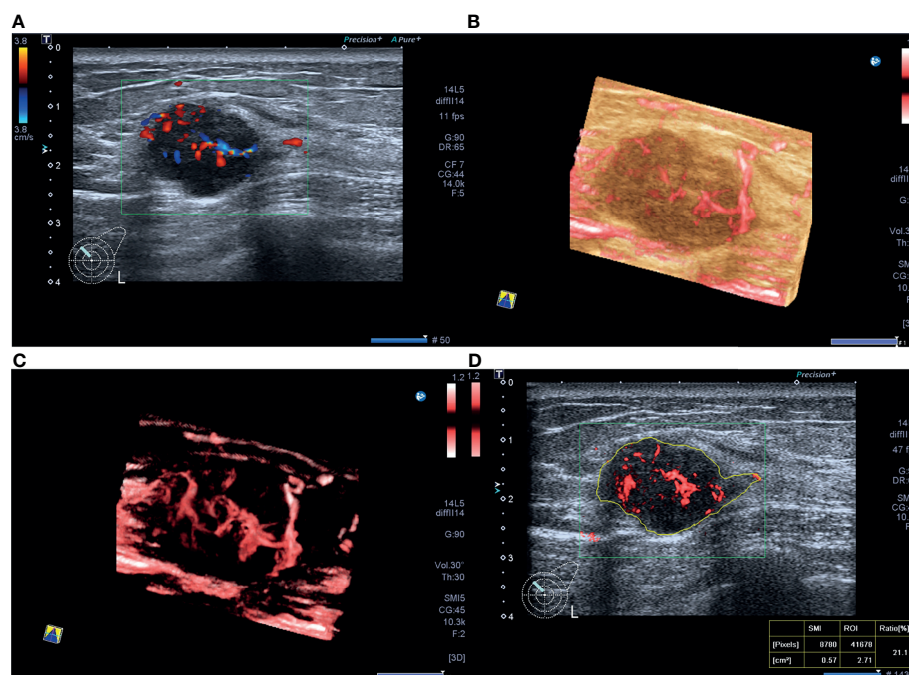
A 40-year-old woman with triple-negative invasive ductal cancer [2.3 cm, ER (-), PR (-), HER-2(-), Ki-67 95%, nuclear grade 2, T2N1M0]. (A) Color Doppler flow image shows abundant and disordered blood flow signals. (B, C) Smart three-dimensional superb microvascular imaging reveals detailed and abundant vascular architecture with crab claw-like blood flow. (D) Vascular index was measured on the plane containing the most abundant vasculature with a value of 21.1%.
